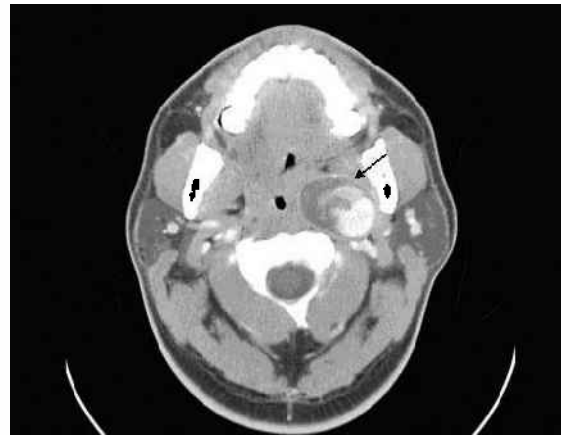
Axial CT image shows a large, left ICA pseudoaneurysm with a thick non-opacified sac into which the contrast is leaking (arrow). The oropharynx is seen to be narrowed on the left.
